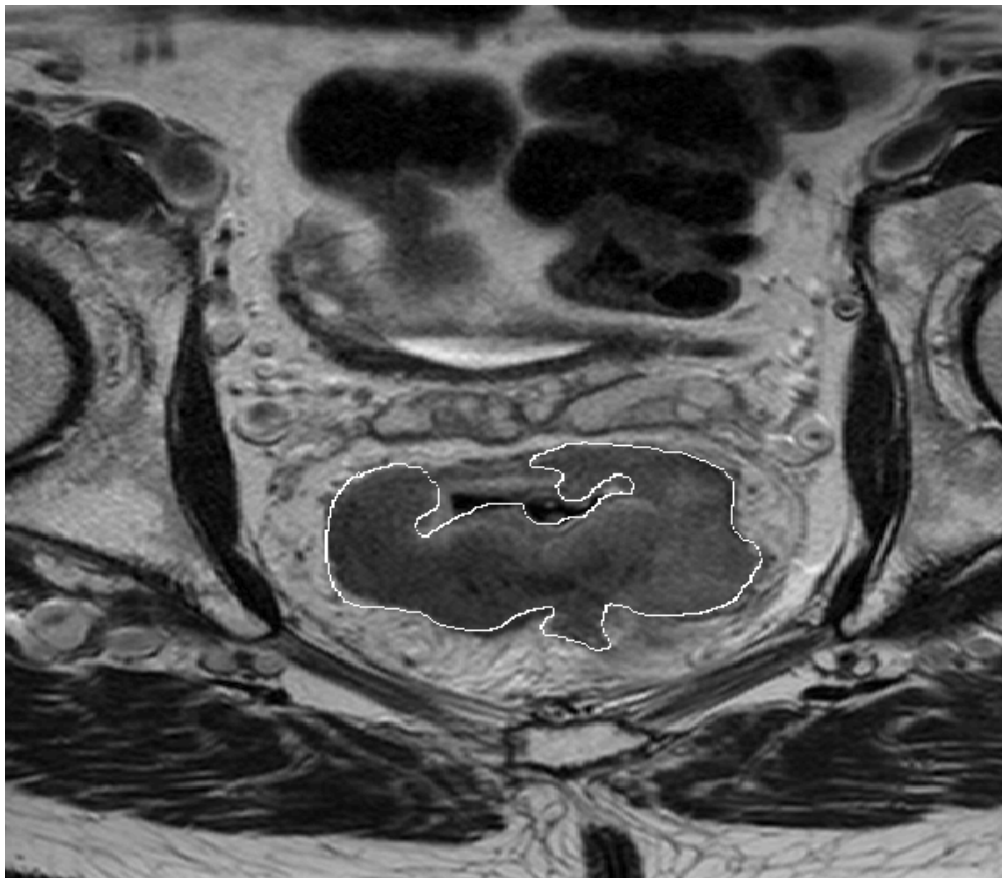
A high quality (526 x 526) T_2 -weighted axial MR image of one of the patients in the Oxytarget study. Drawn by an experienced radiologist, the delineated area indicates the tumour.
